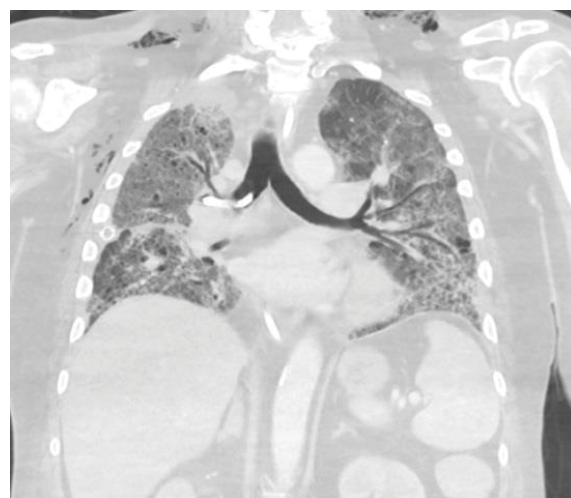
Chest CT (coronal view) showing pigtail in the right mainstem bronchus - without arrows.
